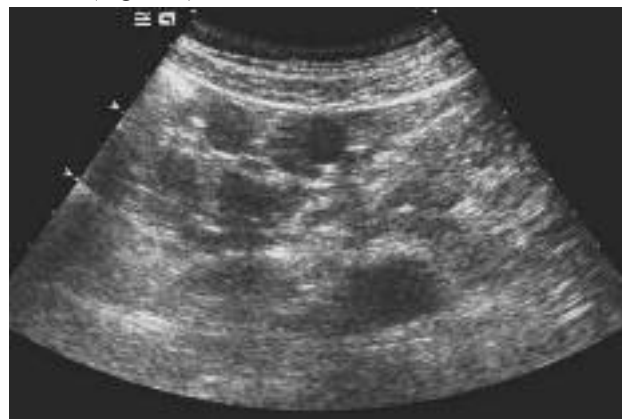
Ultrasound reveals multiple round nodules around the left kidney
